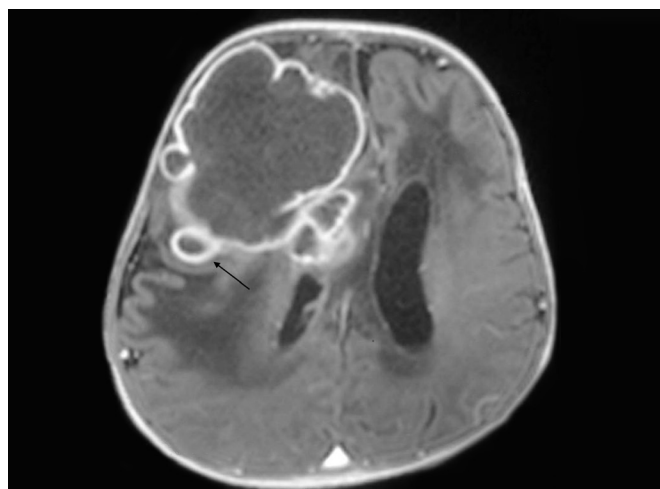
Axial T1-weighted MRI section with gadolinium in a 4-month-old infant shows presence of a large intracerebral abscess with budding daughter cysts. Associated vasogenic edema and midline shift could also be seen
